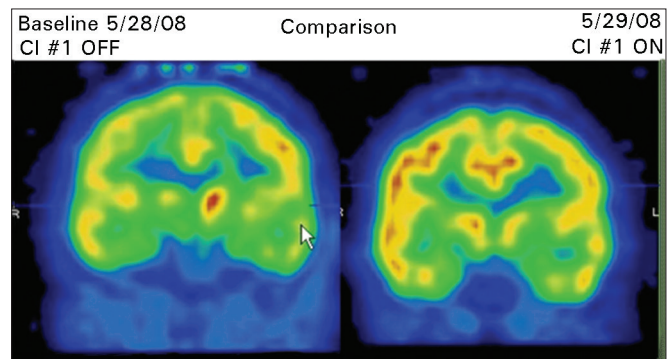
5/28/08; 5/29/08. Before and after activation of cochlear implant sequential FDG scan coronal images reveal that following activation of cochlear implant which produced greater tinnitus especially of the right side (R), FDG activity is markedly elevated in ipsilateral right thalamus and primary auditory cortex. There is persistent medial temporal lobe hypometabolism, now worse on the left (L). The primary auditory cortex is identified (arrow Lt).
